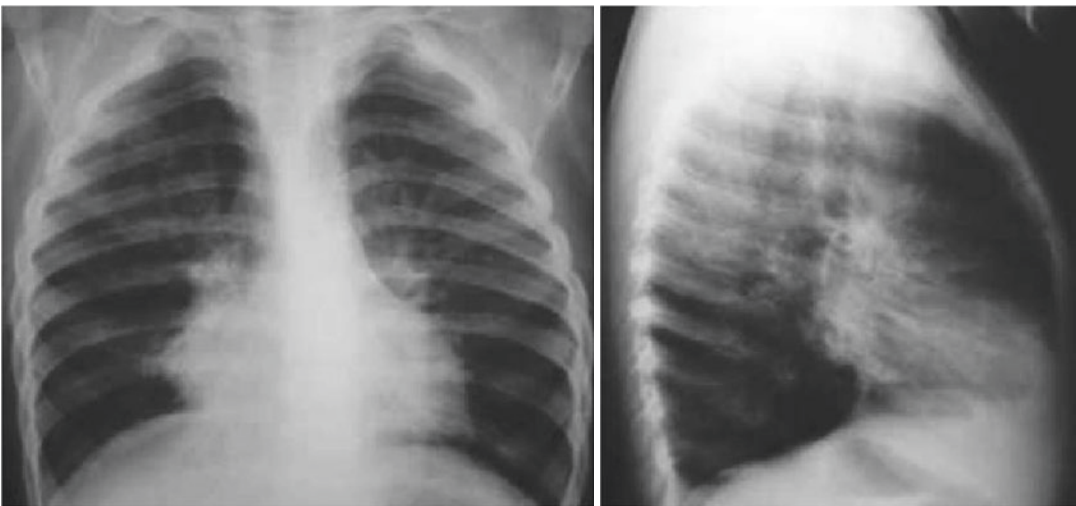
Post-infectious bronchiolitis obliterans (PIBO). Chest X-ray of a 7-year-old schoolchild shows air trapping, atelectasis, and bronchiectasis
